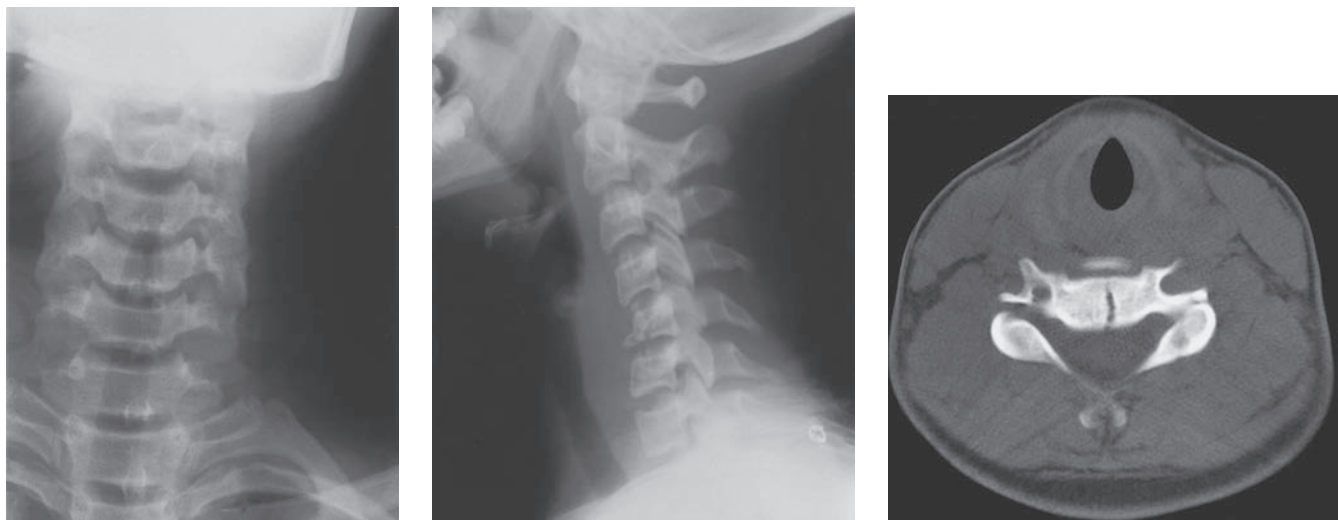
Anteroposterior and lateral radiographs and CT scan of patient with a minimally displaced burst fracture of C5.
